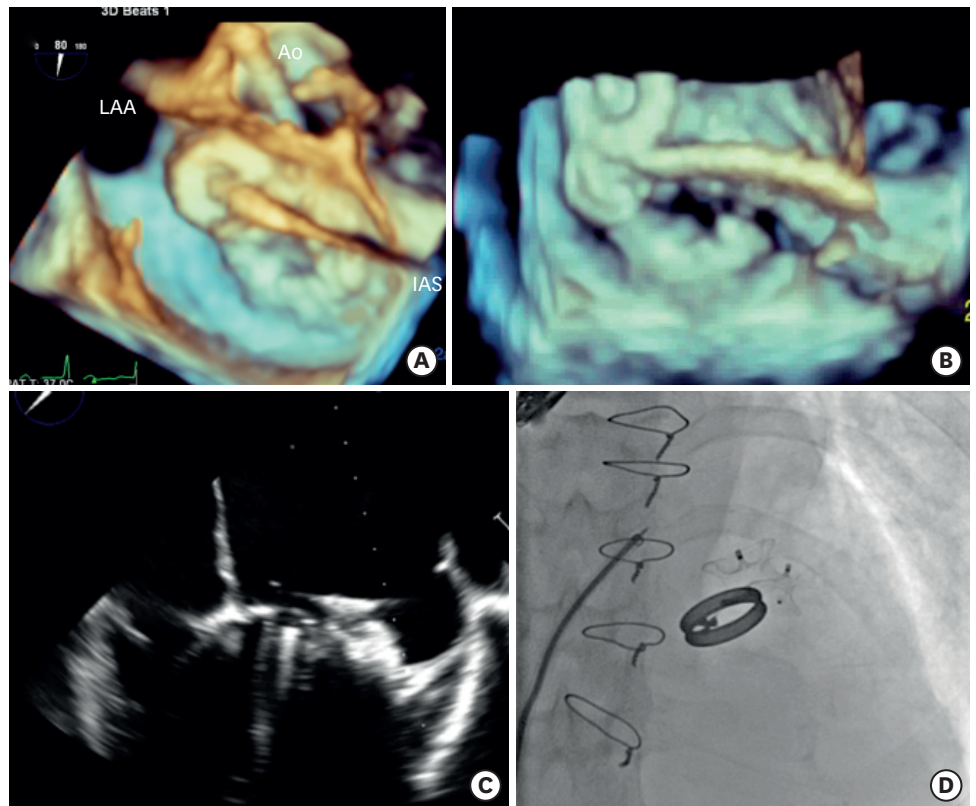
Left atrial enface view on 3-dimensional transesophageal echocardiogram during deployment of the first device (A) and second device (B) shows appropriate and stable position of the device that was confirmed after release of the cable in 4 chamber view (C). The stability of the 2 interlocked devices was confirmed on fluoroscopy (D) in right anterior oblique view (Movie 2). Ao: aorta, IAS: inter atrial septum, LAA: left atrial appendage.
